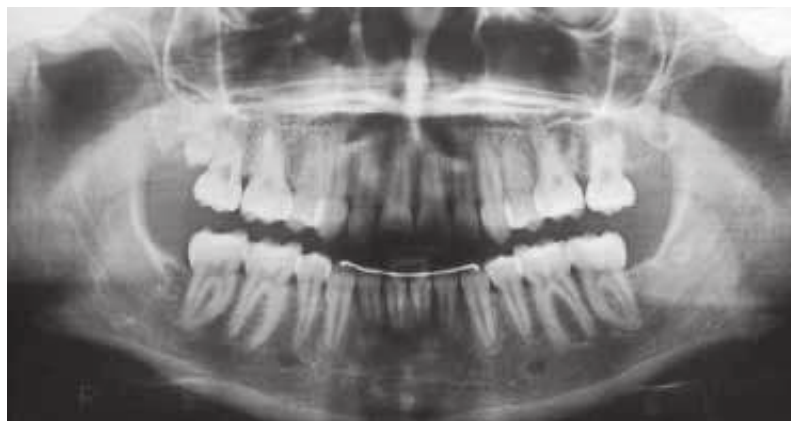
Final panoramic radiograph.
